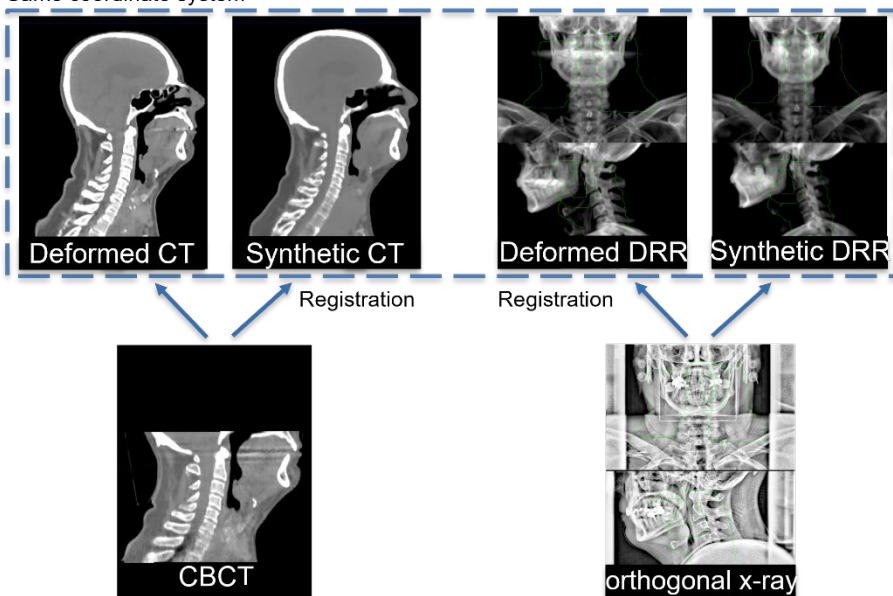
The methodology for Paper II. The digitally reconstructed radiographs (DRR) and the synthetic DRR originate from the planning computed tomography (CT) and synthetic CT, respectively. The 2D manual and 3D automatic registration techniques used in the study were the same techniques used for treatment setup verification in the clinical setting.
